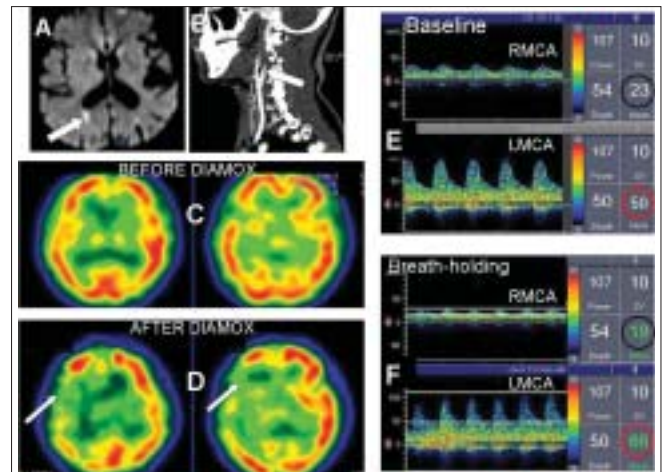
Hemodynamic consequences of a right carotid artery occlusive disease. Diffusion-weighted MRI of the brain (A) shows an acute right posterior 'border-zone' infarction. Occlusion of the right internal carotid artery (B) is noted just distal to the carotid bulb on CT angiography of the cervical vessels. HMPAO-SPECT performed at baseline (C) shows adequate perfusion in both cerebral hemispheres. SPECT images obtained after challenge with acetazolamide (Diamox) revealed markedly reduced perfusion in the right cerebral hemisphere (D). Transcranial Doppler ultrasonography (E and F) was performed for vasomotor reactivity assessment, with breath-holding and monitoring of flow in both middle cerebral arteries (MCA) simultaneously. A normal response is noted on the left side (mean flow velocity increased from 50 cm/s to 66 cm/s after 30 s of breath-holding, with a breath-holding index of 1.07), while the mean flow velocity showed a paradoxical reduction (from 23 cm/s to 19 cm/s), suggestive of a failed vasodilatory reserve
